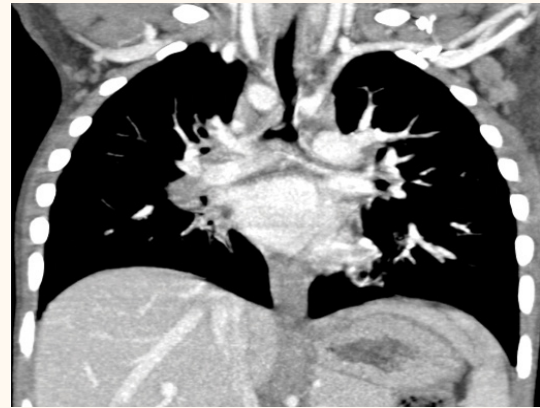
Coronal computed tomography angiography image of the second case, showing both aortic arches compressing the distal trachea.
